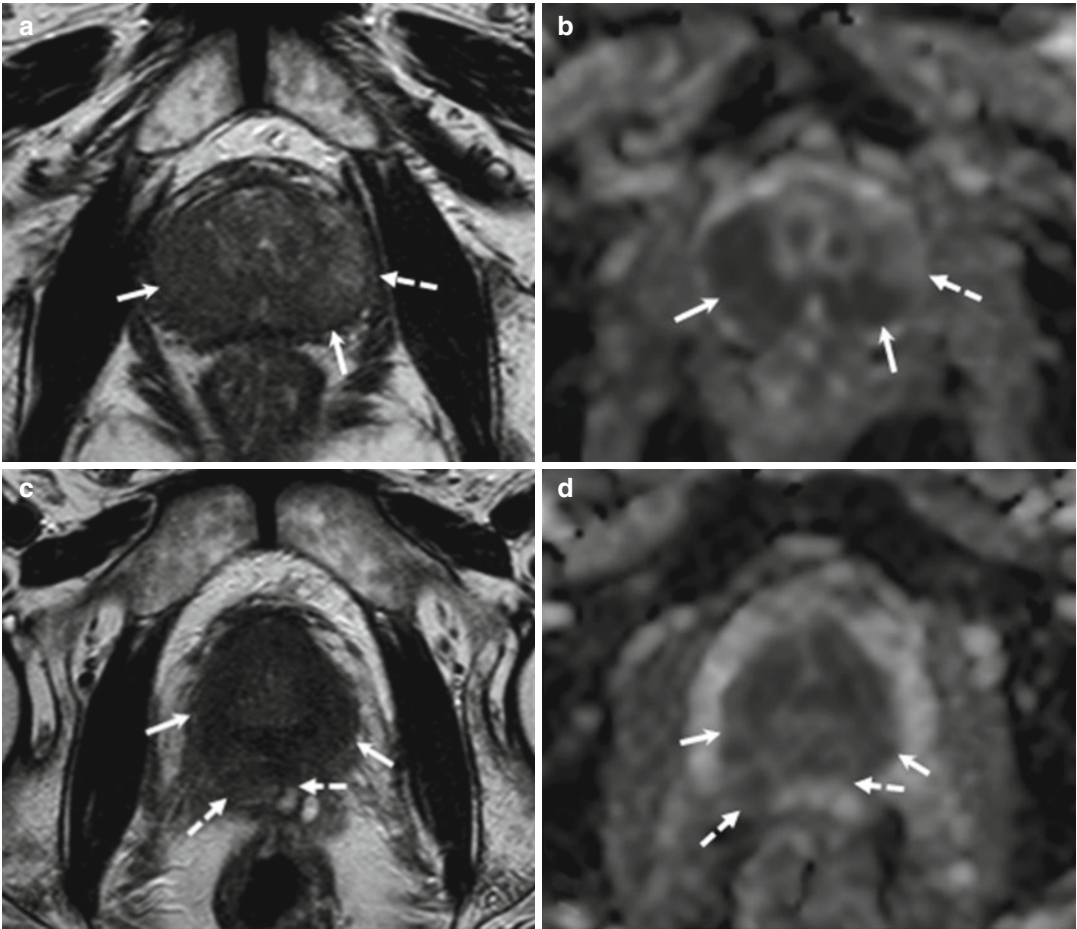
(a–j) 52 years old, Gleason 7 (3+4). On axial T2-weighted (TR: 4074; TE: 100) (a) and ADC (b) sequences, acquired at the middle third, a diffuse hypointensity of the peripheral zone (arrows) is observed, with the exception of the peripheral zone of the left lobe (dashed arrows). On the same sequences (respectively, c and d), at the upper third, the hypointensity involves the entire peripheral zone (arrows), spreading posteriorly and infiltrating both seminal vesicles (dashed arrows), which appear irregularly hypointense, more evident in the right. On axial post-contrastographic phase sequence (e), at the level in c and d, the entire peripheral zone is hypervascularized (arrows). On coronal T2-weighted (TR: 4013; TE: 100) sequence (f), the entire upper third of the prostate is markedly more hypointense than the two lower thirds. On
